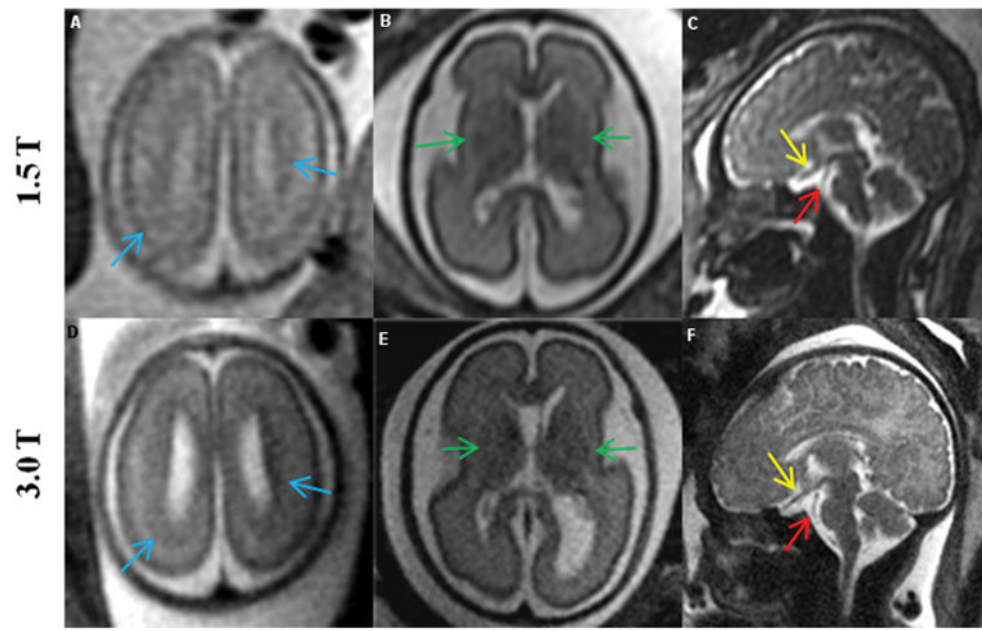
Comparison of 1.5T (top row) vs. corresponding 3.0T (bottom row) MR images of the fetal brain, showing the advantages of increased resolution at 3.0T. 1) Blue arrows (A, D) show the pattern of migration more clearly at 3.0T; 2) green arrows (B, E) show increased contrast in the germinal matrix; and 3) yellow and red arrows (C, F) show clear delineation of the optic nerve and basilar artery, respectively, at 3.0T. Images in the top row and the corresponding images in the bottom row are from the same fetus. Gestational age (weeks) at the time of scan were: (A: 22, D: 22 3/7); (B and E: 26 1/7) ; (C: 35 1/7, F: 35 4/7).
